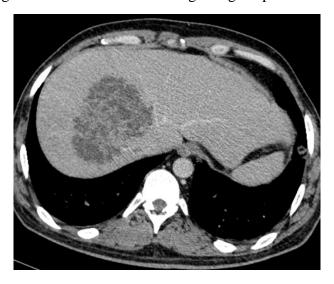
axial CT scan showing a large hepatic abscess
